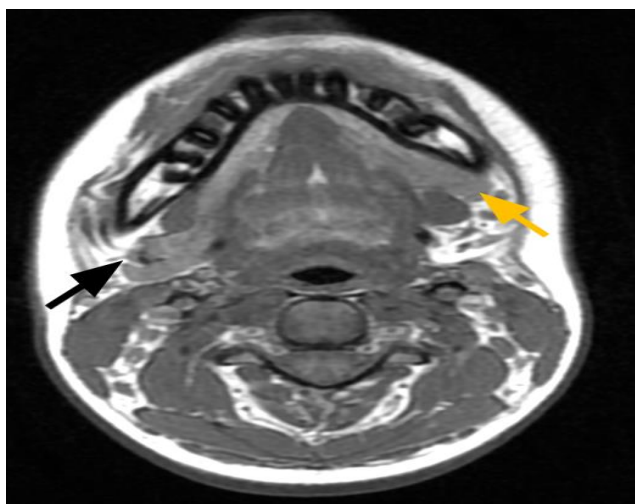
Axial T1W MRI images showing hypertrophied right sublingual gland (black arrow) extending into the right submandibular area and hypertrophied left sublingual gland (yellow arrow) herniating through ipsilateral anterior mylohyoid muscular defect.
